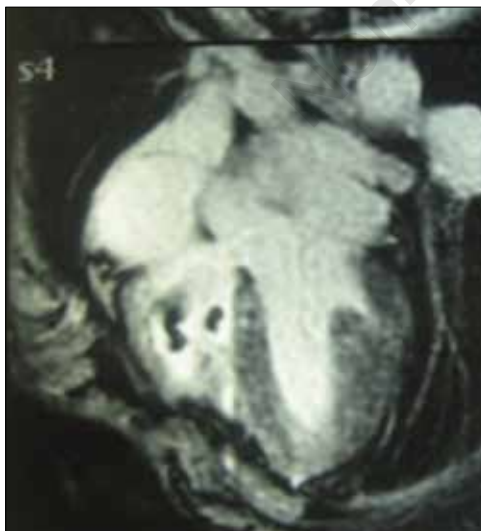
Cardiac magnetic resonance image (four chamber view) showing two right intracardiac thrombi.
